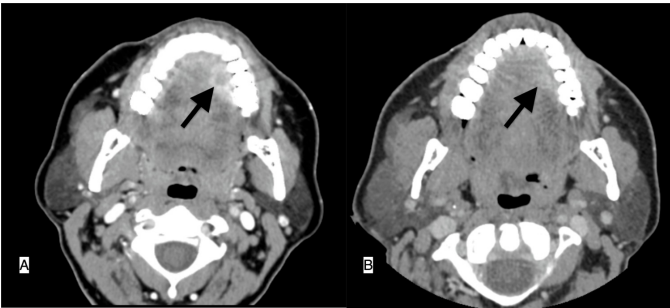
(A) Contrast-enhanced axial computed tomography image obtained before treatment shows a hypodense abscess with enhancement of the peripheral rim of the tongue (arrow). (B) Axial CT demonstrates near-complete resolution of the abscess on the ninth day after drainage (arrow).
